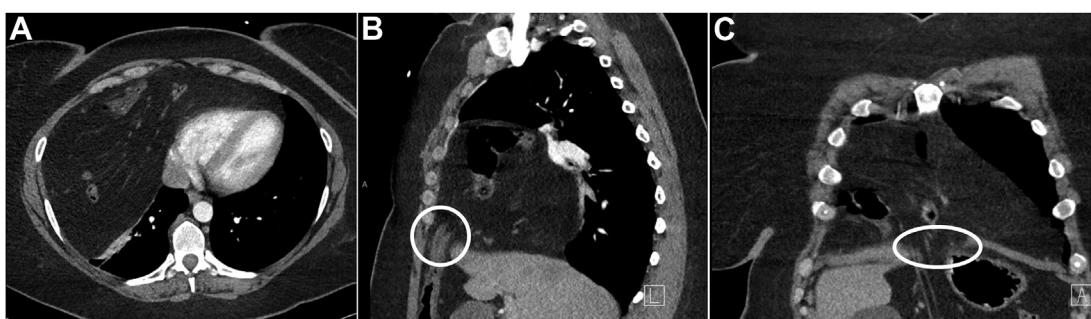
CT imaging of complex right-sided Morgagni hernia containing omentum, small intestine, and large intestine. (A) Axial, (B) Sagittal, (C) Coronal. White circle depicts anterior hernia defect.
